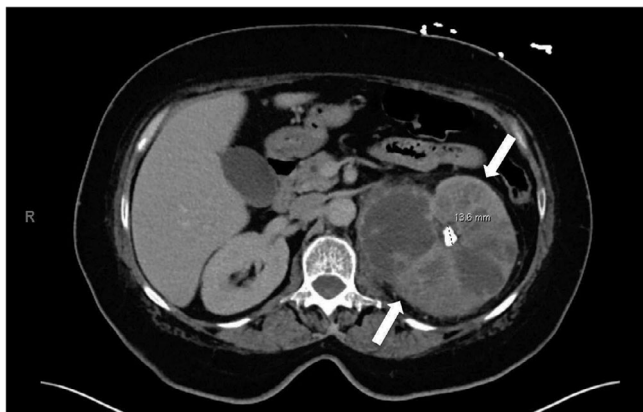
Axial computed tomography (CT) of the abdomen showing large fluid filled locules in the left kidney (white arrows) with thick septations and a stone in the infundibulum.
